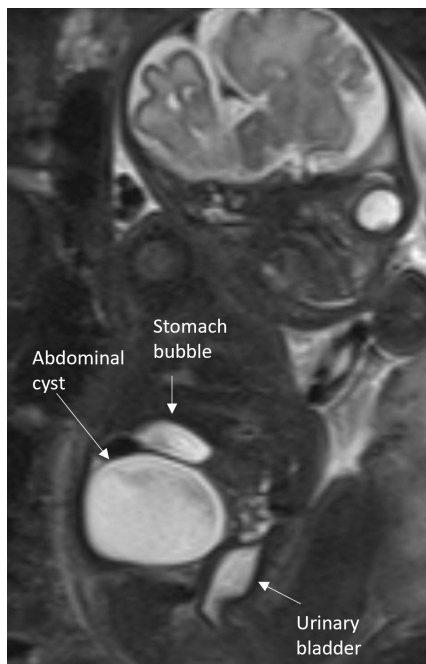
T2 HASTE STIR Coronal MRI image of abdominal cyst in 32+2 week fetus
